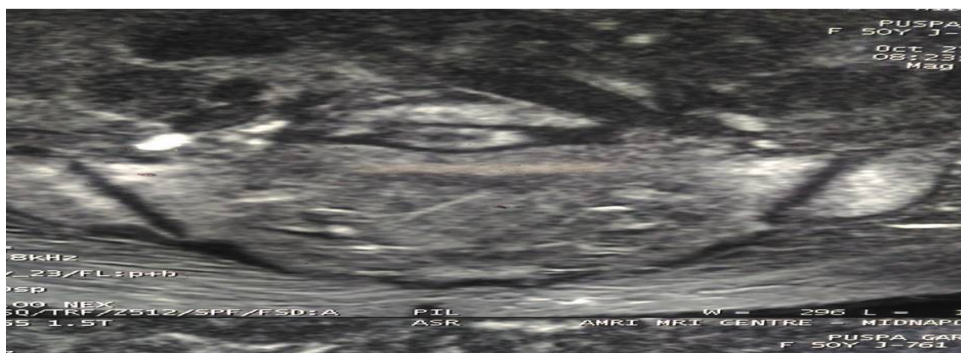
MRI SI joint shows bilateral sacroiliitis.
